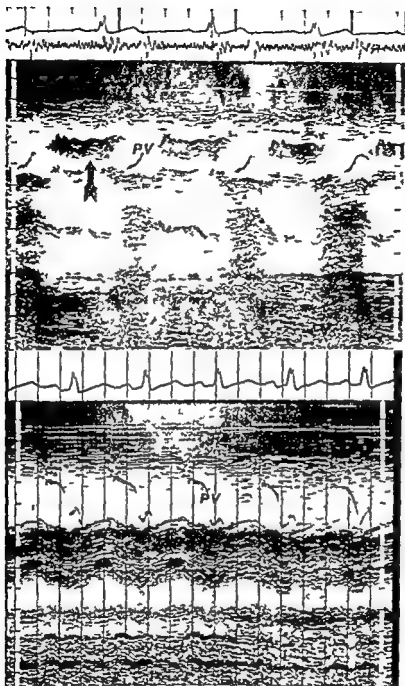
A (top panel) M mode echocardiogram of pulmonic valve shown, dense echoes beneath the pulmonic valve (PV) during diastole (arrow) B (bottom panel) M mode echocardiogram of pulmonic valve (PV) postoperatively demonstrating absence of dense reflectances beneath pulmonic valve seen preoperatively The A wave amplitude is prominent
